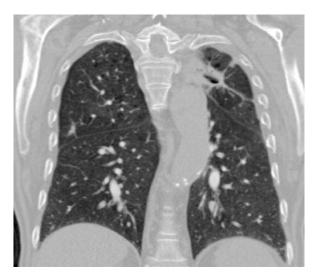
Chest CT control after 4 months, coronal plane. Lung window setting shows a marked cicatricial retraction in the upper left lobe with associated an empty cavity. Evident diffuse signs of COPD (phenotype B: emphysema and chronic bronchitis) coexist in both lungs.
